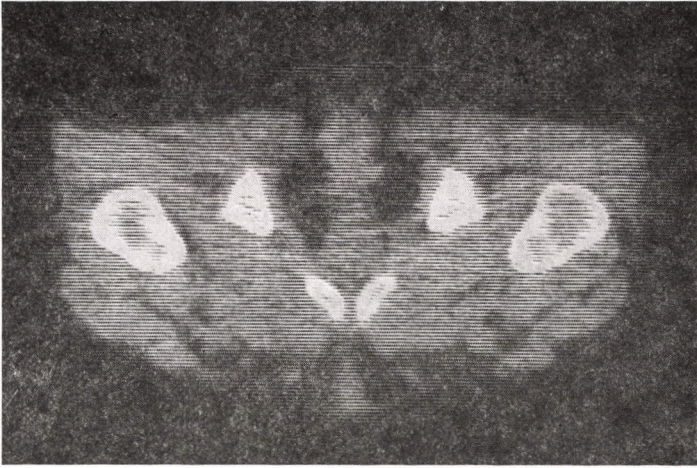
CT scan of local (sacral) recurrence
